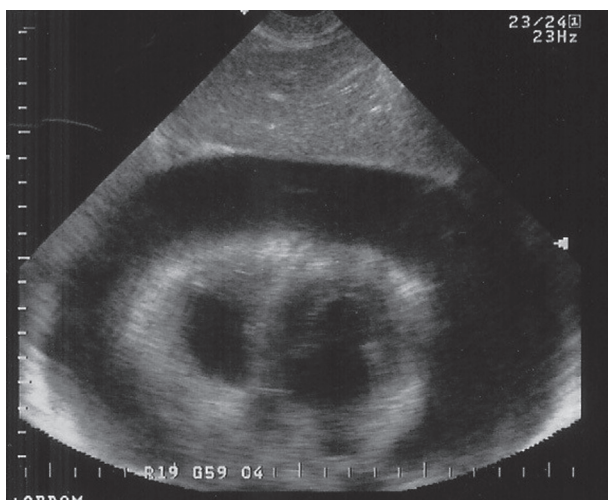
Echocardiogram demonstrating pericardial fluid with cardiac tamponade.
